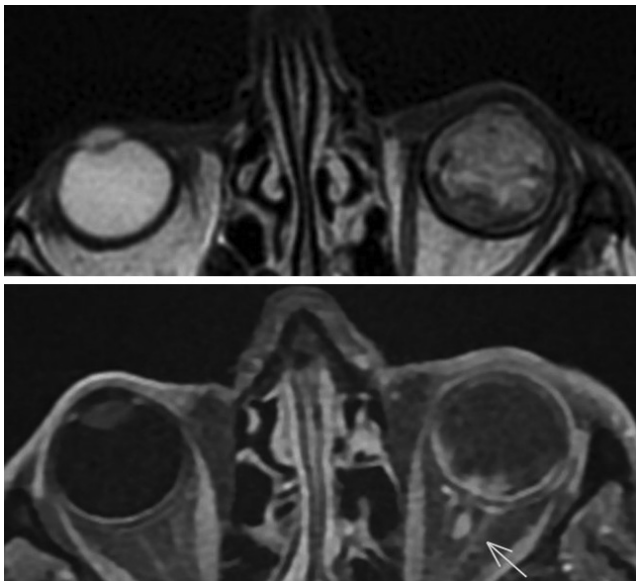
Patient 2, MRI: tumor located at the posterior aspect inside the left globe (a) and the extension into the optic nerve (b) (arrow).
